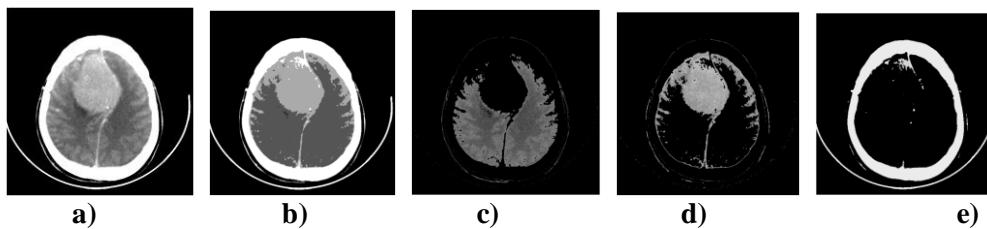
11 k-means algorithm applied on CT slice (3 classes in this case)
